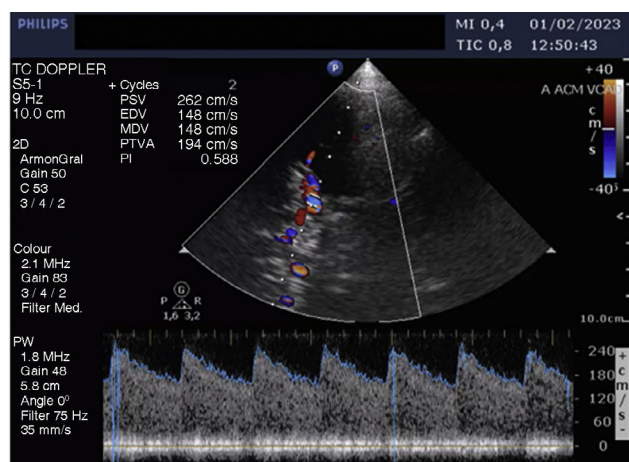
Transcranial Doppler ultrasound image. Diffuse acceleration of the middle cerebral artery.
